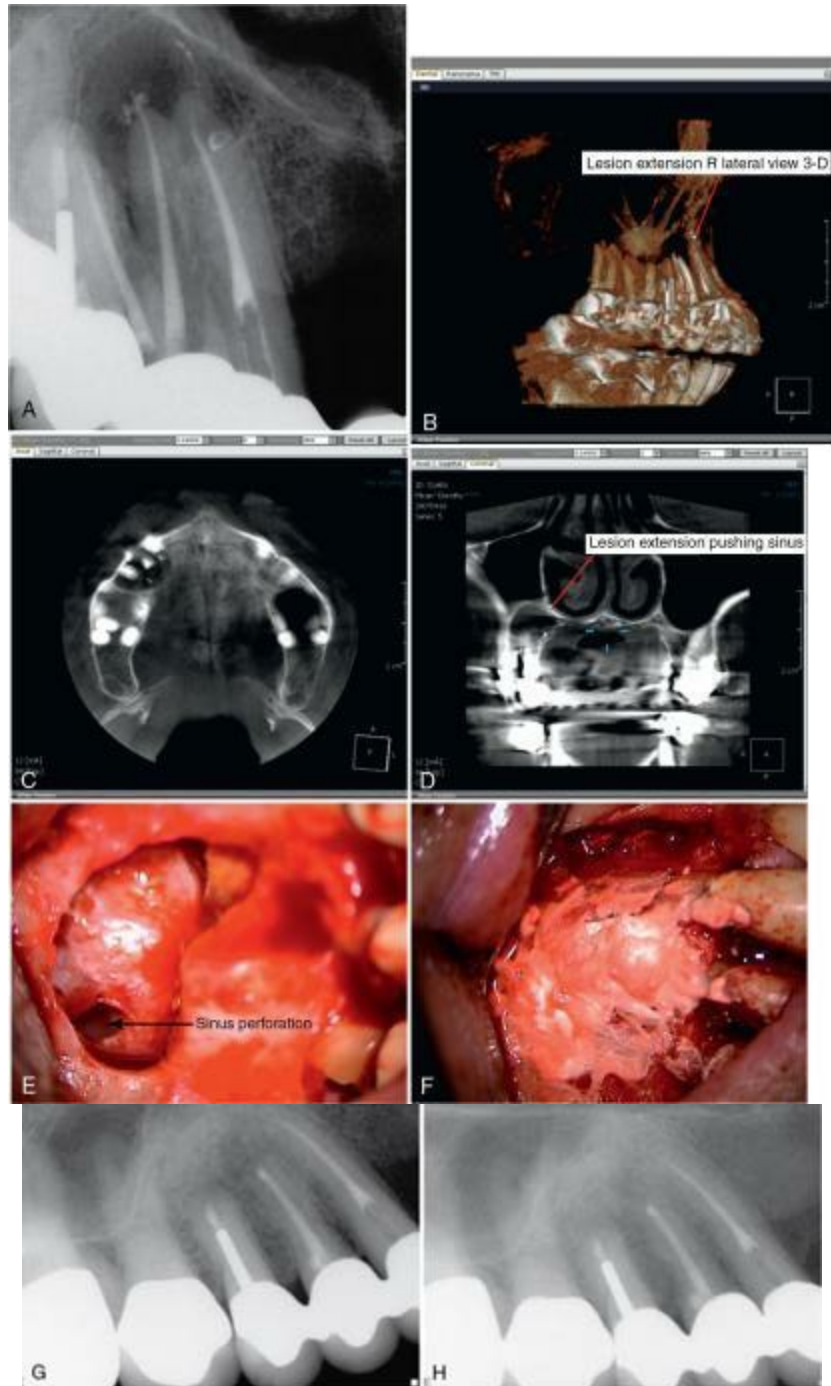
A, Preoperative periapical radiograph showing large radiolucency associated with teeth #4, 5, and 6. B, CBCT reconstruction (*lateral view*). Rotation of the 3D volume on a computer monitor demonstrated that intact bone was present around the apex of tooth #6 and the lesion was associated only with #4 and 5 (this could not be detected with multiple angled periapical radiographs). C, Axial CBCT view demonstrating facial-palatal extent of the lesion. D, Coronal CBCT view showing displacement of the sinus membrane (a finding that suggests a sinus membrane perforation will be detected during
